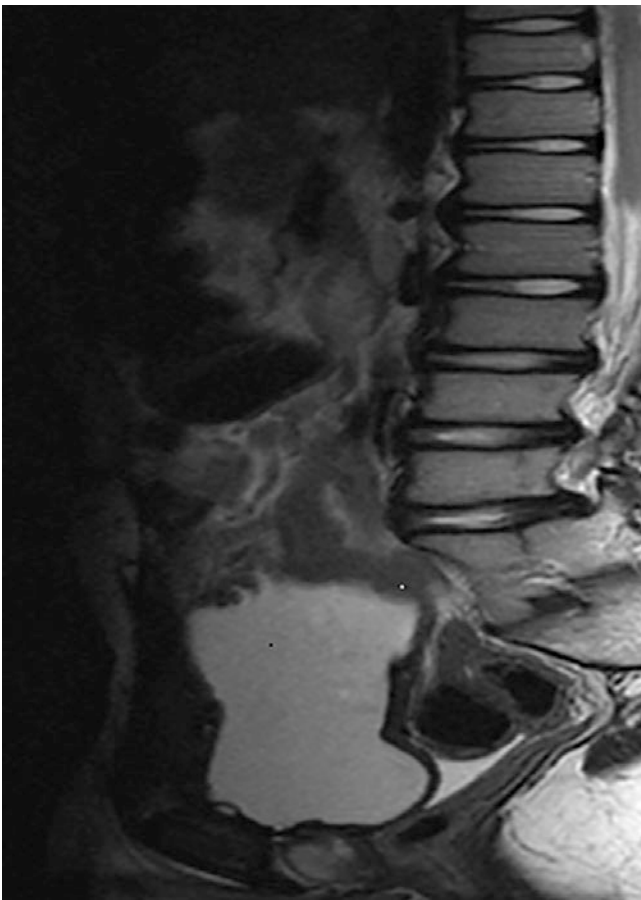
Sagittal lumbosacral spine MRI image of the caudal regression sequence, showing hypoplastic sacral segments of spine (image courtesy of Dr. Alice Patton). Patients with this disorder may have associated small iliac wings, imperforate anus and hypoplasia of the external genitalia and lower extremities
